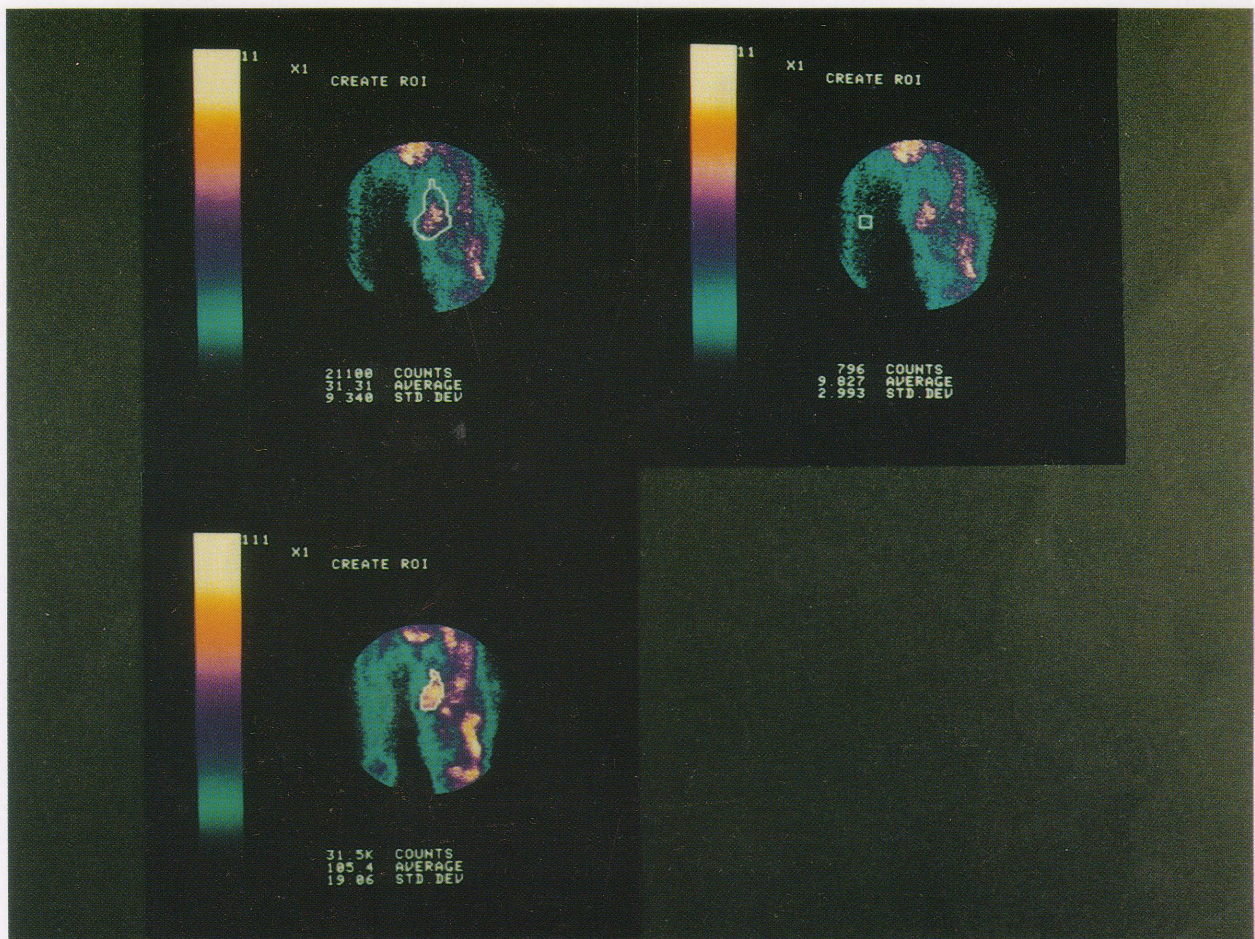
Immunoscintigrams of the femoral region. (Upper left) ROI for the calculation of tumor uptake. Its size was greater than the surface area of the tumor because of the low resolution of detector system. (Upper right) ROI for the calculation of the background level included in the tumor ROI. (Lower left) ROI for the determination of the surface area of the tumor.
